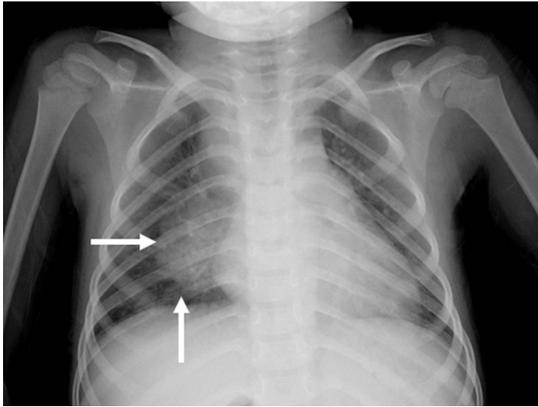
Chest radiograph showing mediastinal widening and mass-like opacity (arrows) in the right lower lung field.
